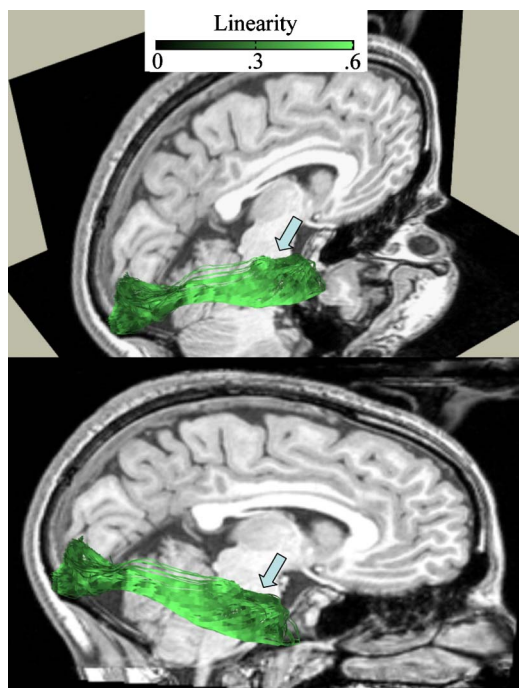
Linearity index along the OR. The linearity index is sampled at 1-millimeter arc length. The linearity index value is shown by the inset. The T1-weighted background image is a sagittal right hemisphere slice, near the bottom of the calcarine sulcus. The two images show the same data from different viewpoints. Subject S2.
